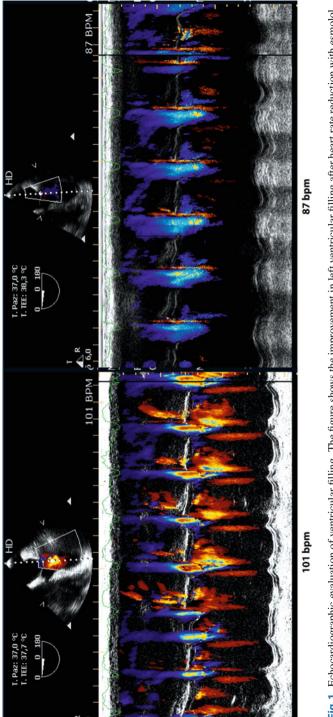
Echocardiographic evaluation of ventricular filling. The figure shows the improvement in left ventricular filling after heart rate reduction with esmolol. bpm: beats per minute
